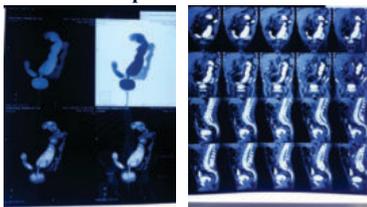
Contrast enhanced CT Scan of abdomen with pelvis
